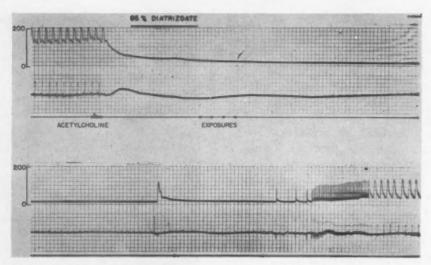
Femoral arterial pressure and lead II recorded during temporary cardiac arrest with acetylcholine, injection of contrast media, x-ray exposure and spontaneous return of cardiac rhythm.
